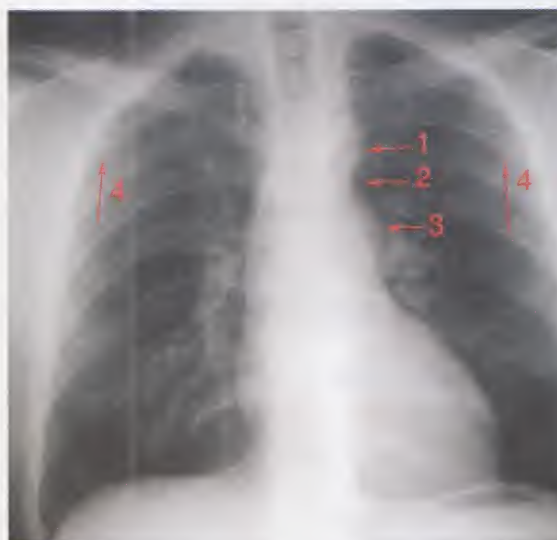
Plain chest x-ray, aortic coarctation. The aortic knob (1), the coarctation (2), the post-stenotic dilation of the descending aorta (3) and rib notching caused by the dilated intercostal arteries (4).
